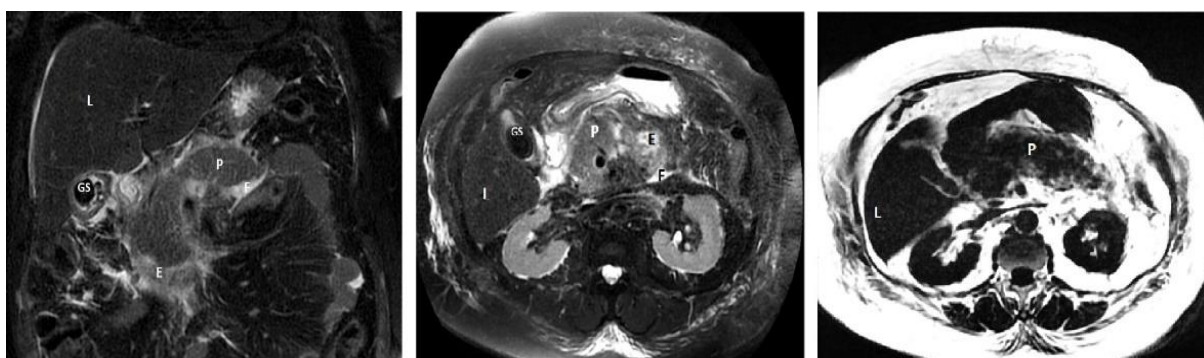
Axial MRI and CT findings: Gallstones, acute inflammatory changes of the pancreas and peripancreatic soft tissue (Authors' unpublished data).
